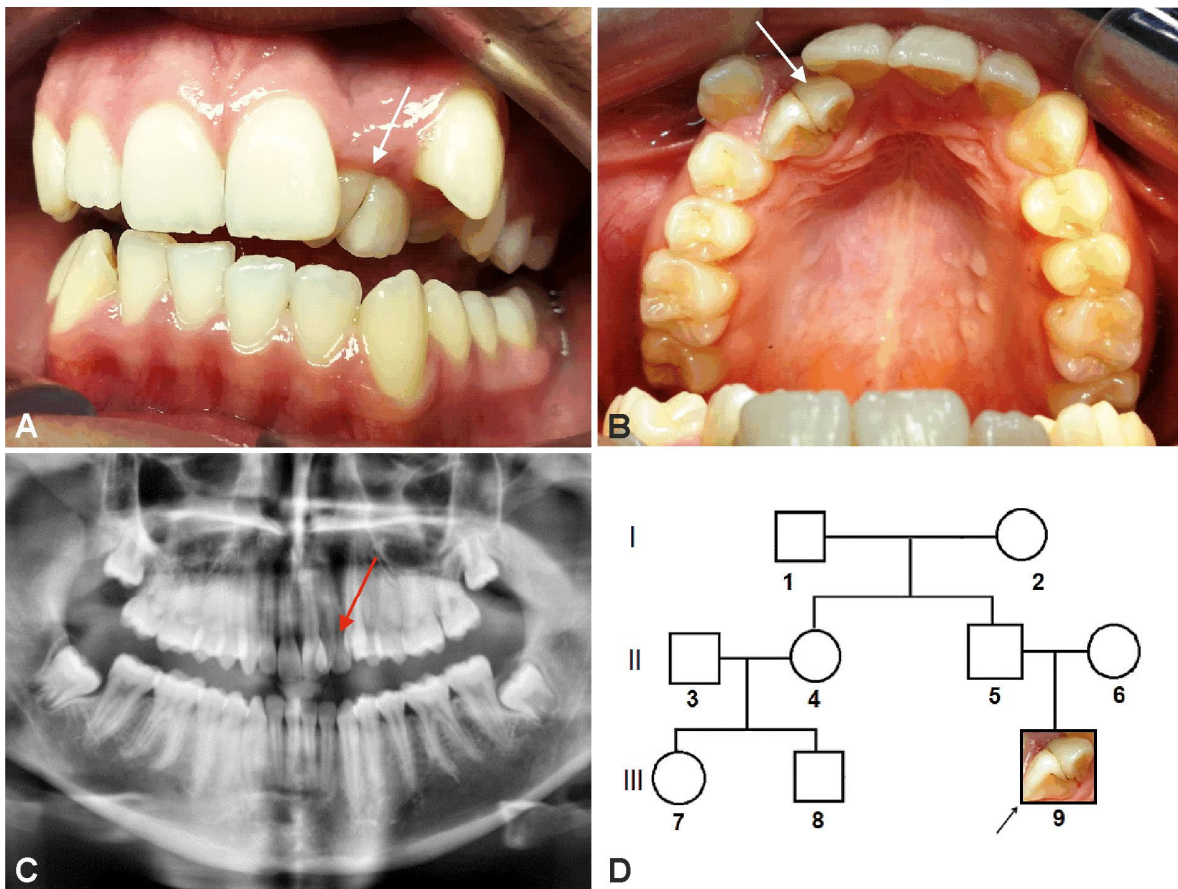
Supernumerary upper permanent lateral incisor because of gemination (2.2 bis) – isolated, sporadic, non-hereditary, nonsyndromic case (15-year-old boy). Half-lateral intraorally view with teeth separated (A) and occlusal intraoral view of upper arch (B): clinical dental phenotype and particular appearance of the upper arch; panoramic radiograph showing the supernumerary tooth (C); the family tree: isolated, sporadic case (D).
